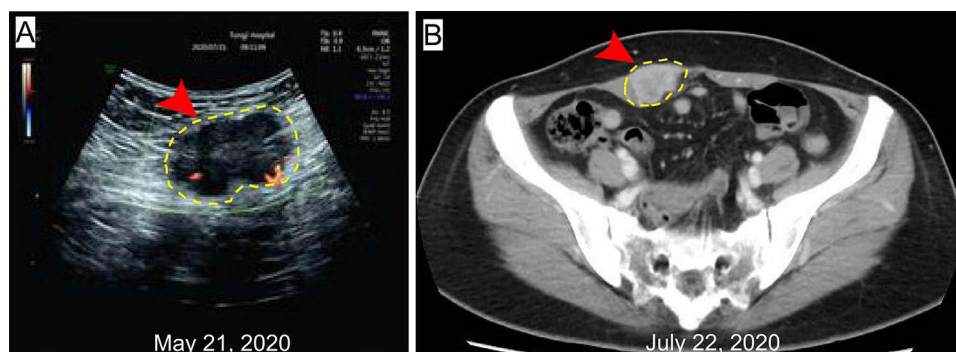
Imaging results of the patient in Case 2. (A) Ultrasound showed subcutaneous mass in the abdominal wall (4.1 cm × 2.2 cm) on May 21, 2020 (red arrow and yellow outline); (B) CT indicated abnormal enhanced nodule of right rectus abdominis (3.1 cm × 2.3 cm) on July 22, 2020 (red arrow and yellow outline).
